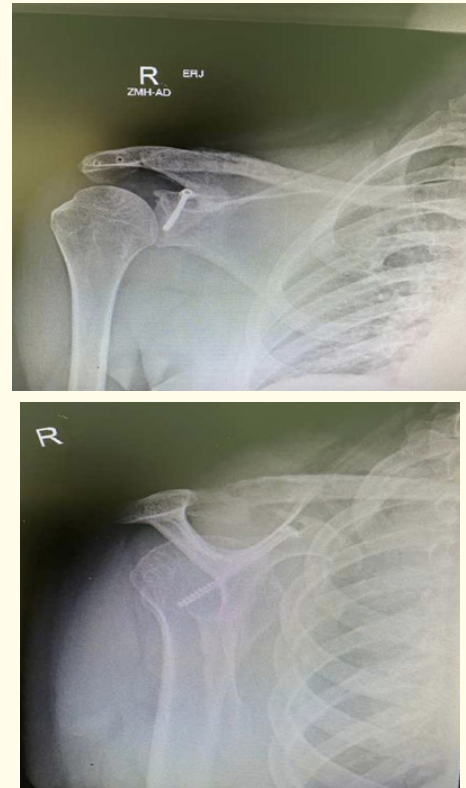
X-rays post removal of hardware.
